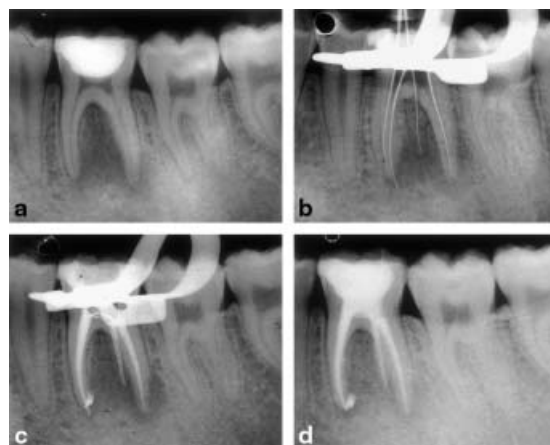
(a) Preoperative radiograph of tooth 36 showing the presence of the radix entomolaris projected on the distal root. (b) Length-determination radiograph of the conventional root canals (one distal root canal and two mesial canals) and the root canal of the radix entomolaris. (c) Radiographic control following obturation of the four root canals. (d) One-year postoperative radiographic control indicating healthy apical bone structure with no radiographic signs of apical periodontitis.
